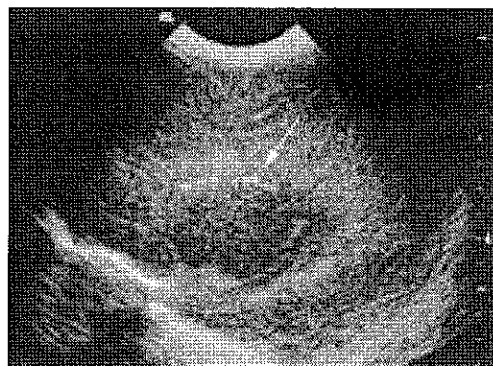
Cranial ultrasound scan showing linear calcification in the brain parenchyma in the parasagittal plane
